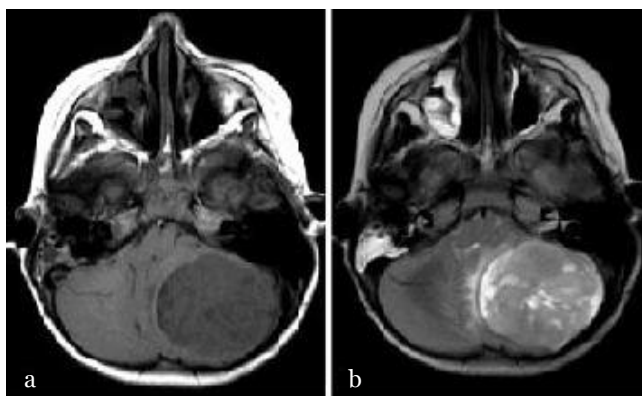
Medulloblastoma*. The inhomogeneous mass on T1 and T2-weighted imaging (a,b).
